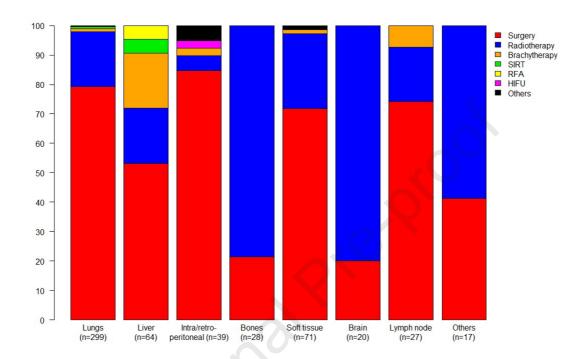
Sites of metastasis and types of local ablative therapy (number of interventions). SIRT: Selective internal radiotherapy, RFA: Radiofrequency ablation, HIFU: High-intensity focused ultrasound.
